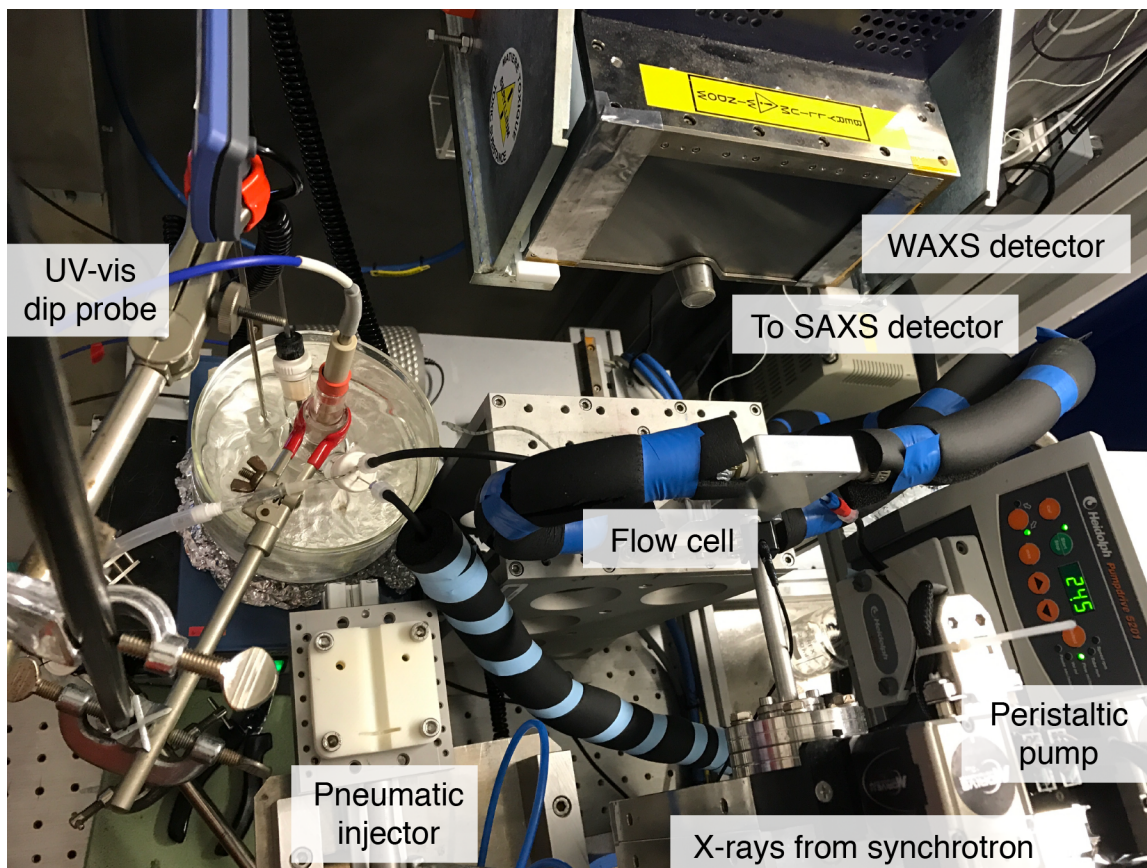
Photograph of synchrotron X-ray experiment apparatus.
